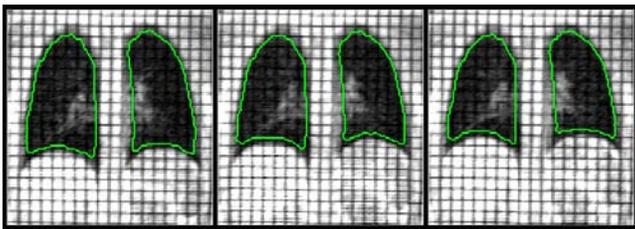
Segmented lung boundary from grid-tagged MR images for three time points from end-inspiration to end-expiration.
